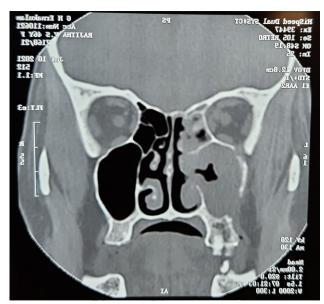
CT scan of case 1. Soft tissue opacification with bony erosion of left maxillary sinus.
